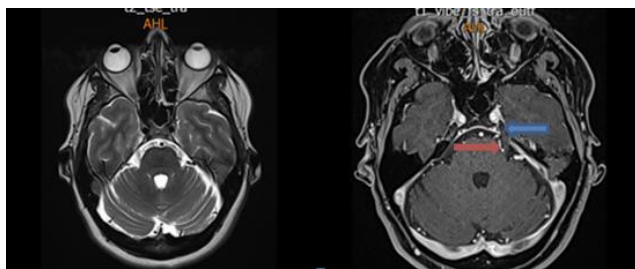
Compression of the left trigeminal nerve by an anterior inferior cerebellar artery in a prepontine cistern on axial MR image, Red arrow: Left anterior inferior cerebellar artery, Blue arrow: Left trigeminal nerve
